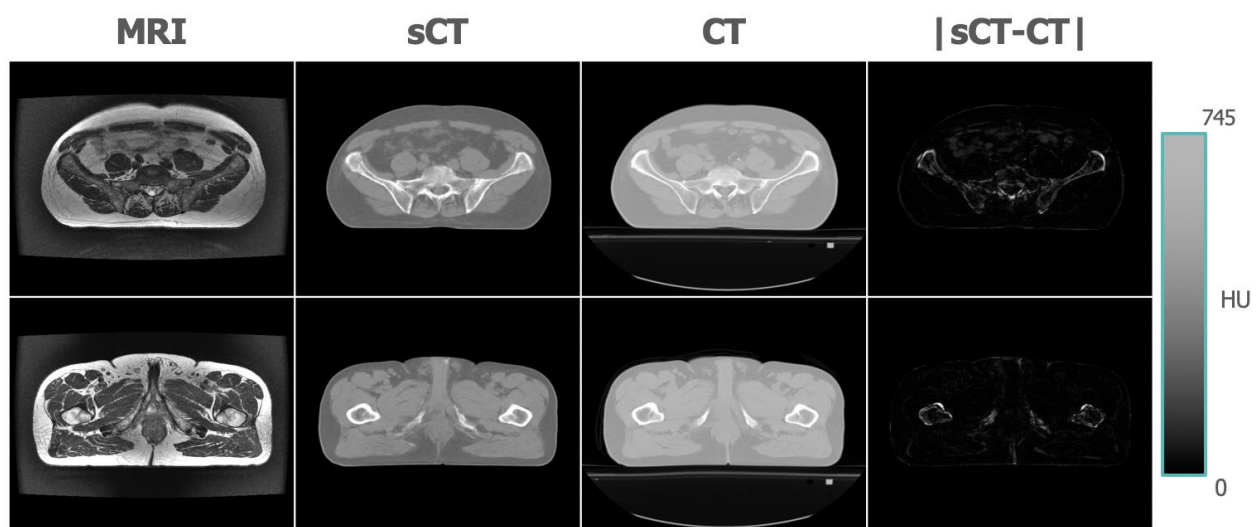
MRI, sCT, CT and $|sCT - CT|$ for an exemplary patient.
